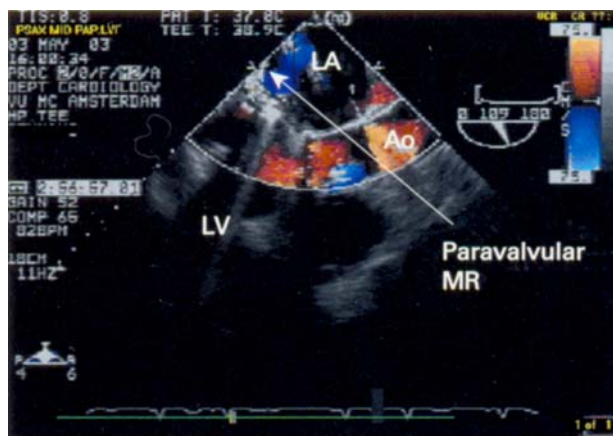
Two-dimensional colour transoesophageal echocardiographic image in systole showing a thickened valve prosthesis with irregular margins (vegetations), and clear signs of dehiscence with a severe resulting paravalvular mitral regurgitation (MR; arrow). Ao = aorta, LA = left atrium, LV = left ventricle.
